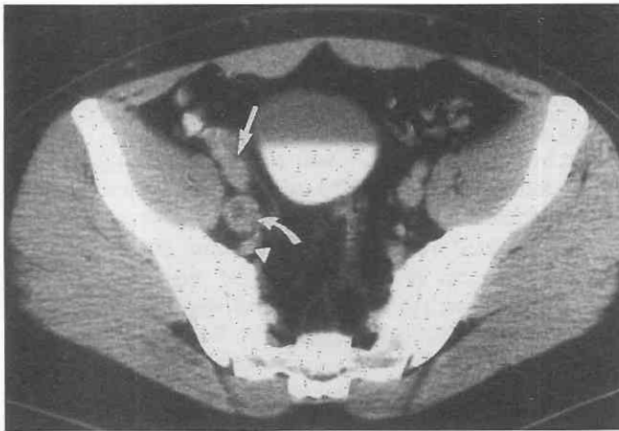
Pelvic lymph nodes. CT scan through the bifurcation of the external iliac artery and vein anteriorly (*straight arrow*) and the internal iliac vessels posteriorly (*arrowhead*) shows a classic right hypogastric lymph node metastasis (*curved arrow*) from cancer of the prostate gland.
